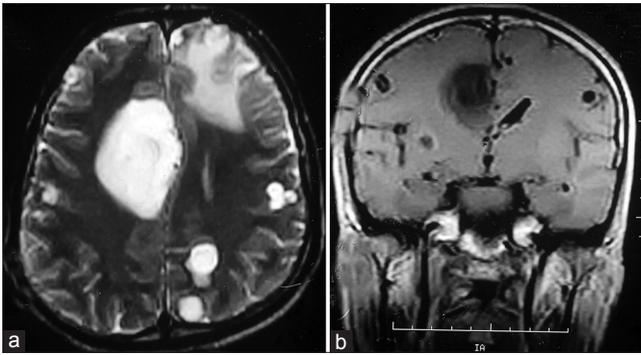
(a) Initial T2W MRI showing multiple cystic lesions along with predominant enhancing lesions in the corpus callosum (2009) (b) Initial contrast enhanced T1 weighted MR showing corpus callosal Glioma along with coexistent Neurocysticercosis (2009)
